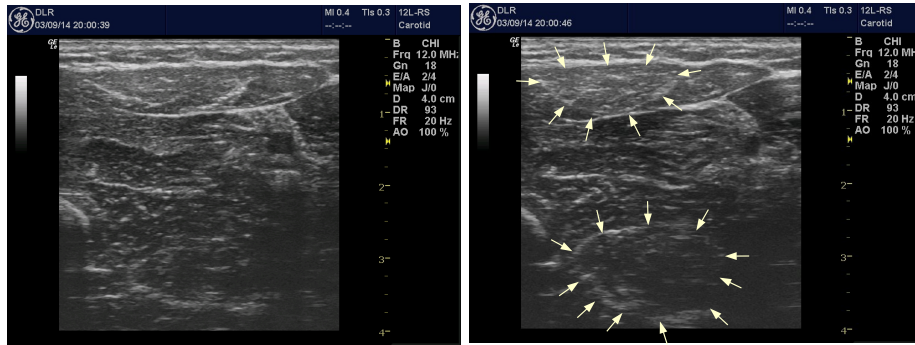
Left index finger flexion recorded with ultrasound, placed as depicted in Figure 11.
